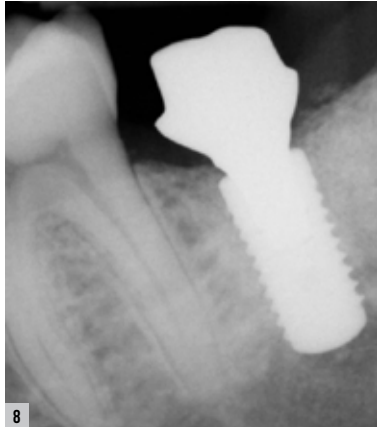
A radiograph confirms proper placement of the implant and abutment. Fig. 9: The final crown is cemented with 3M™ ESPE™ RelyX™ Unicem 2 Self-Adhesive Resin Cement. The implant is left slightly out of occlusion to allow for the natural compression that occurs on adjacent teeth under heavy occlusion. Fig. 10: A radiograph of the completed implant, abutment, and crown. This view confirms no cement remains around the margins or implant.
